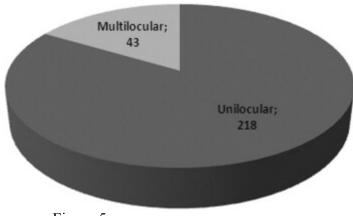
Radiographic aspect of OKCs.
